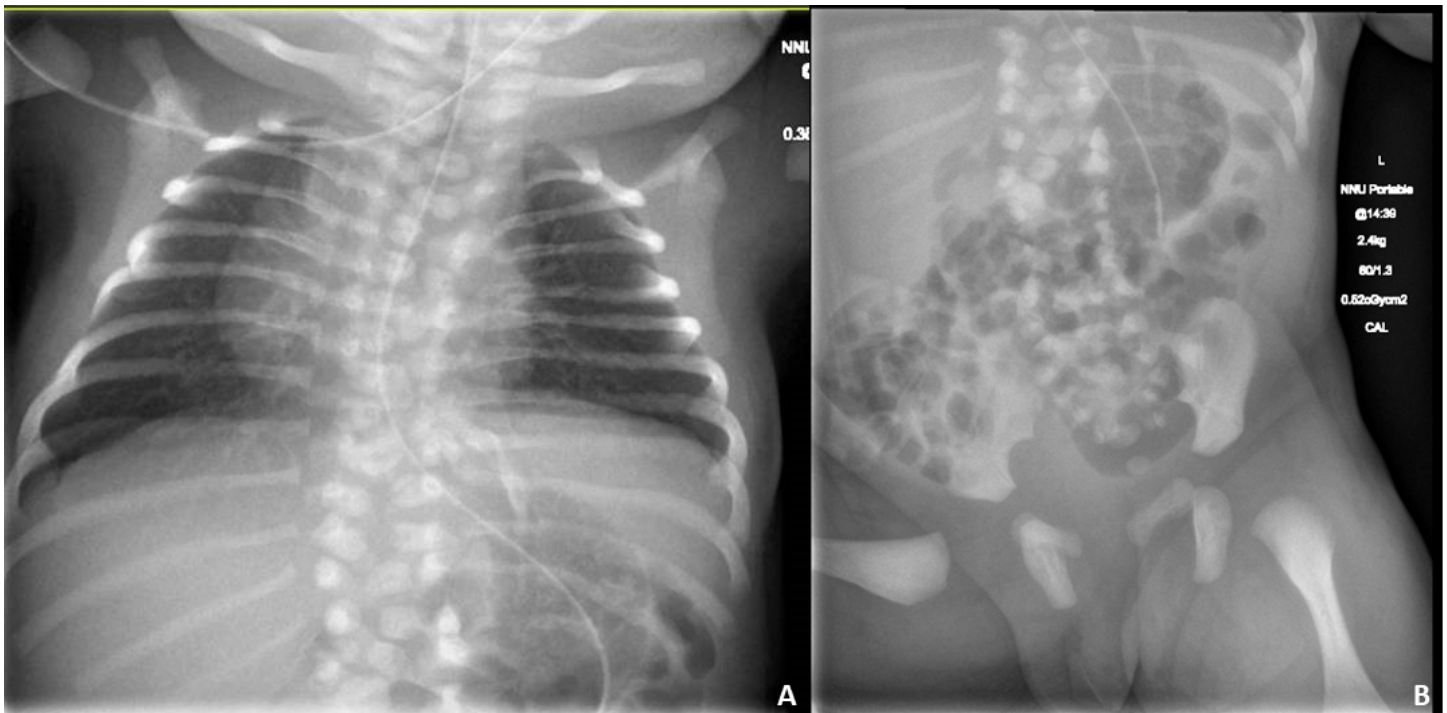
Thoracic (A) and lumbar spine (B) radiographs of an infant with *TBX6*-related SCDO
